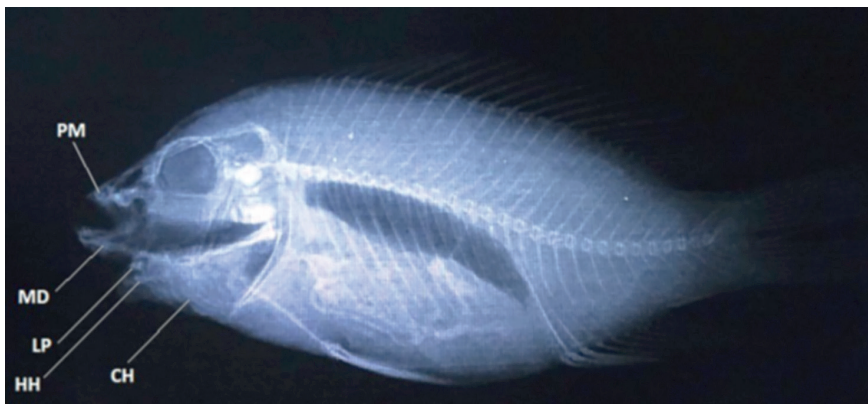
Radiograph of *Coptodon zillii*, 145 mm TL showing the bones of the mouth and hypobranchial areas. CH, ceratohyals; HH, hypohyals; LP, lingual plate; MD, mandible; PM, premaxilla.
